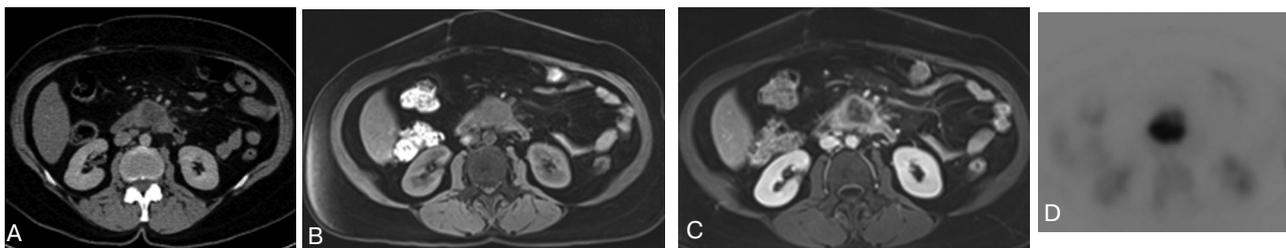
Pancreatic adenocarcinoma. A. Axial contrast-enhanced CT image shows infiltrative hypodense lesion in neck of pancreas B. On unenhanced T1-weighted MR image, this hypovascular tumor presents as a low-signal-intensity mass. C. On post-gadolinium T1-weighted MR image, it is clearly separated from normal enhancing pancreatic tissue. This sequence also shows the secondary finding of pancreatic duct dilatation and atrophy of the tail of the pancreas. D. On PET CT image the lesion shows FDG-uptake
